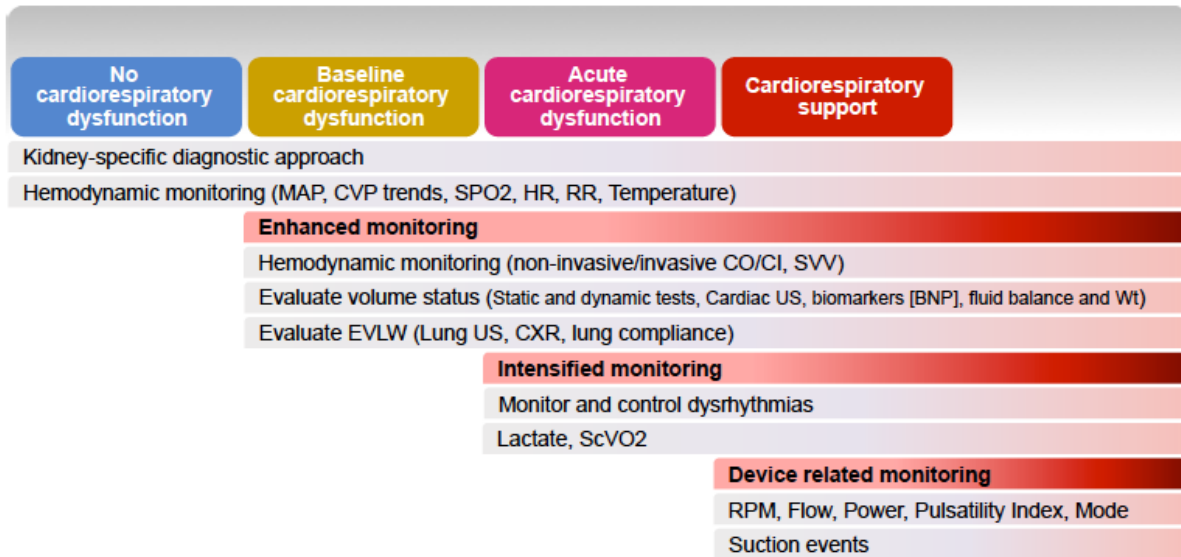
Cardio-Respiratory Specific Diagnostic Approach. A diagnostic approach which may be applied to the patient who has a cardiorespiratory cause for acute kidney injury (AKI) is shown. The level of intervention is governed by the degree and chronicity of cardiorespiratory dysfunction. MAP: mean arterial pressure; CVP: central venous pressure; SpO₂: peripheral oxygen saturation; HR: heart rate; RR: respiratory rate; CO: cardiac output; CI: cardiac index; SVV: stroke volume variation; US: ultrasound; BNP: brain natriuretic peptide; EVLW: extra-vascular lung water; CXR: chest x-ray; ScVO₂: central venous oxygen saturation.
